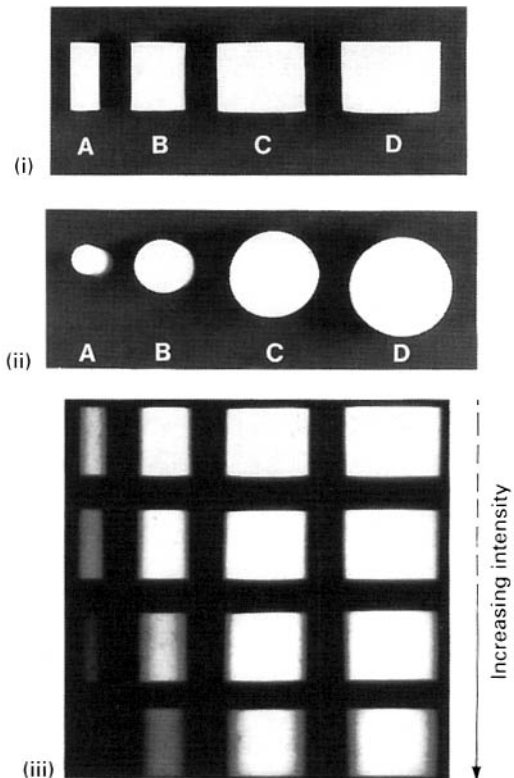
(i) Front view and (ii) plan view of four cylinders made from plaster of Paris but of different diameters. (iii) Four radiographs using different intensity X-ray beams show how increasing the intensity of the X-ray beam causes greater penetration of the object with less attenuation, hence the less radiopaque (white) shadows of the object that are produced, particularly of the smallest cylinder.
